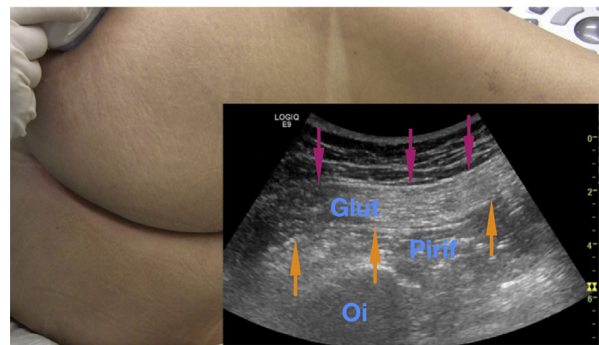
A 6 MHz sonogram of the gluteal region. The muscle layers, but not the respective fascia layers can be clearly differentiated. Magenta arrows: gluteal fascia with fascia of gluteus maximus muscle (Glut), golden arrows: fascias of piriformis (Pirif) and gluteus maximus muscles (Glut).
